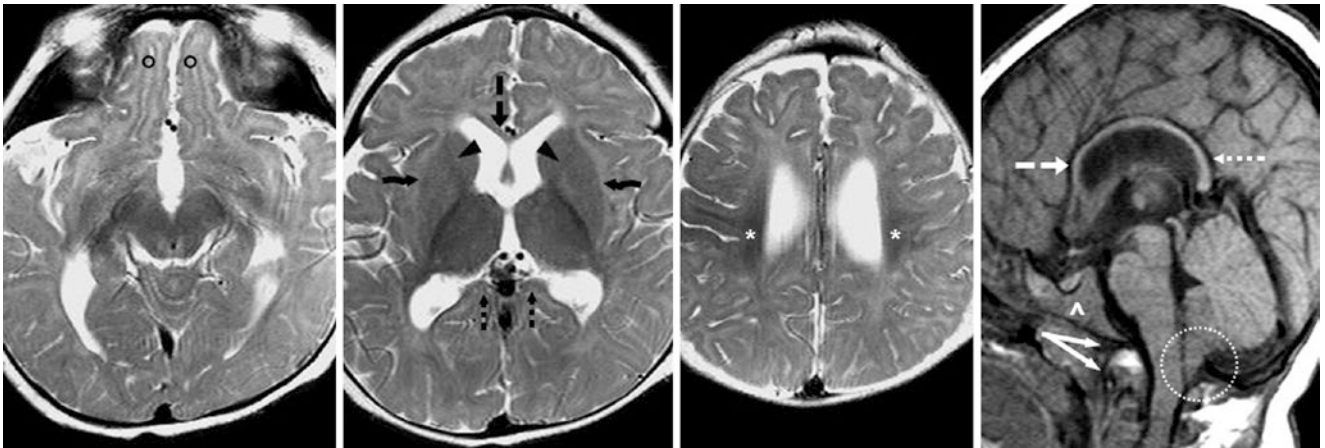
Comparison case of mucopolipidosis II (I-cell disease). A 12-month-old had delayed maturation of deep WM and SCWM on a 3T MRI with SE T2WIs (left three images). The ALIC (arrowheads), CG (dashed arrow), CS (dotted arrows), optic radiations, OFWM (circles), and deep WM anterior to the PRC (asterisks) are poorly myelinated.
